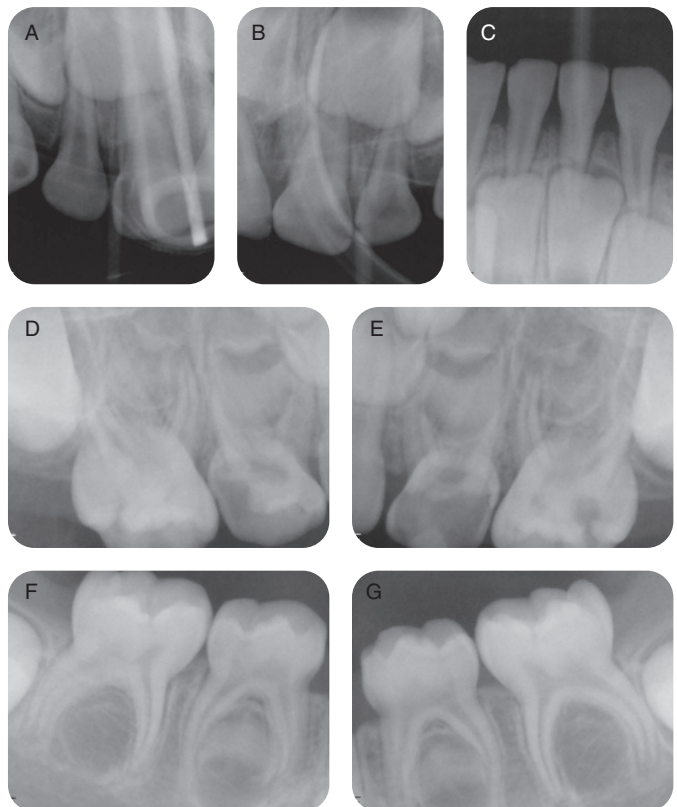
Pre-op Intra-oral radiographs. A. Right maxillary occlusal radiograph, B. left maxillary occlusal radiograph, C. mandibular occlusal radiograph, D. right maxillary periapical radiograph, E. left maxillary periapical radiograph, F. right mandibular periapical radiograph, G. left mandibular periapical radiograph
